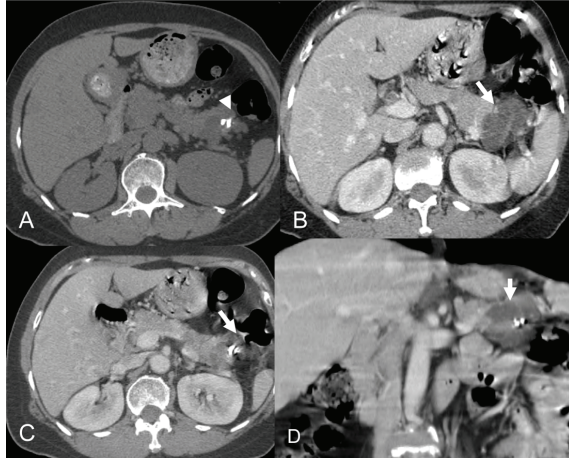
A 54 year-old female with epigastrum pain. Axial non contrast CT scan (A), axial post contrast CT (B, C) and post contrast coronal view (D) show multilocular microcystic lesion (arrow in B, C, D) with central calcification (arrow head in A) at tail of pancreas. The EUS finding (not shown) reveals lobulated mass contained numerous microcyst showing honeycomb appearance at tail of pancreas, compatible with serous cystadenoma
